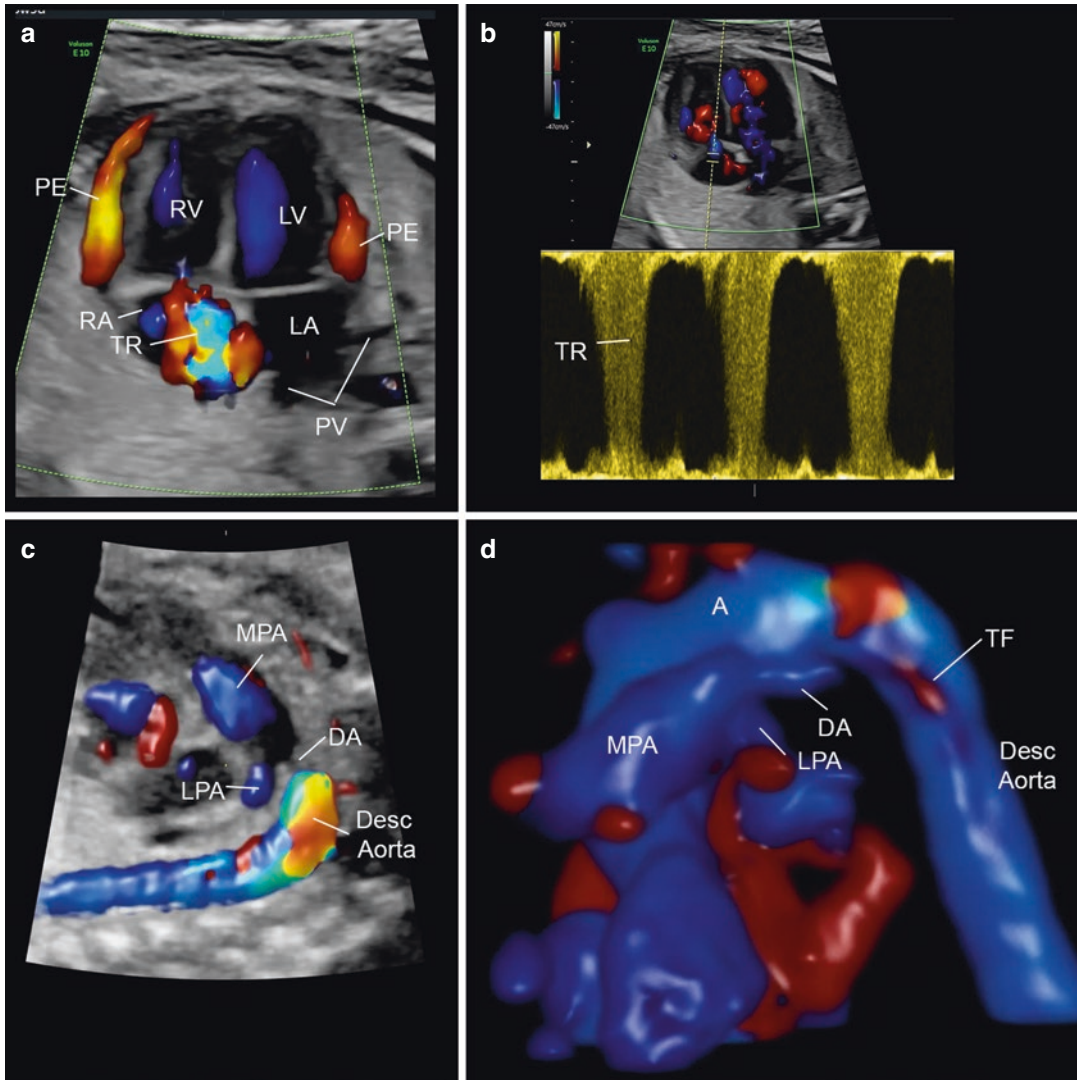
28-week constricted ductus arteriosus. (a) Color Doppler image demonstrating abnormalities that include bilateral pericardial effusions (PE) along the right and left ventricles and tricuspid regurgitation (TR). (b) Pulsed Doppler from the right atrial chamber demonstrates holosystolic tricuspid regurgitation. (c) Short-axis view of the ductal arch demonstrating the narrow ductus
